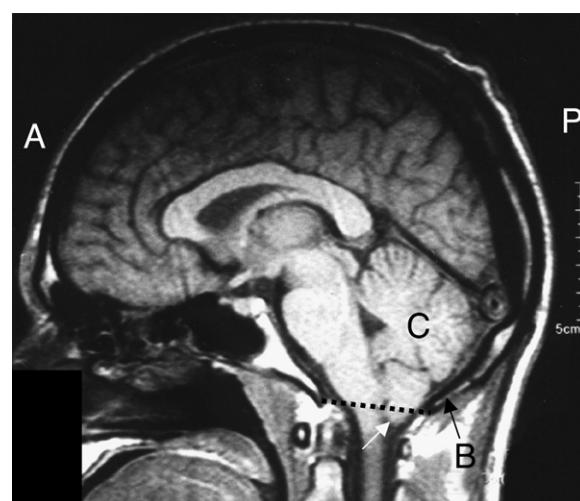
Brain MRI sagittal T1-weighted image showing the 'mild tonsillar herniation' (white arrow) that projects approximately 6 mm below the level of the foramen magnum (represented by the dotted line across that region of the skull). A = anterior; P = posterior; C = cerebellum; B = occipital bone.
